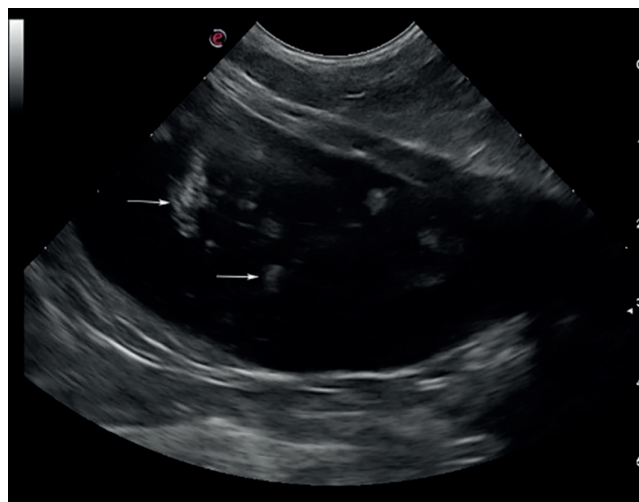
Ultrasonographic appearance of the bladder at the time of preliminary assessment (before initiation of the therapeutic protocol) Semi-fullness, moderate parietal reaction, suspended microlithiasic elements (arrows).
